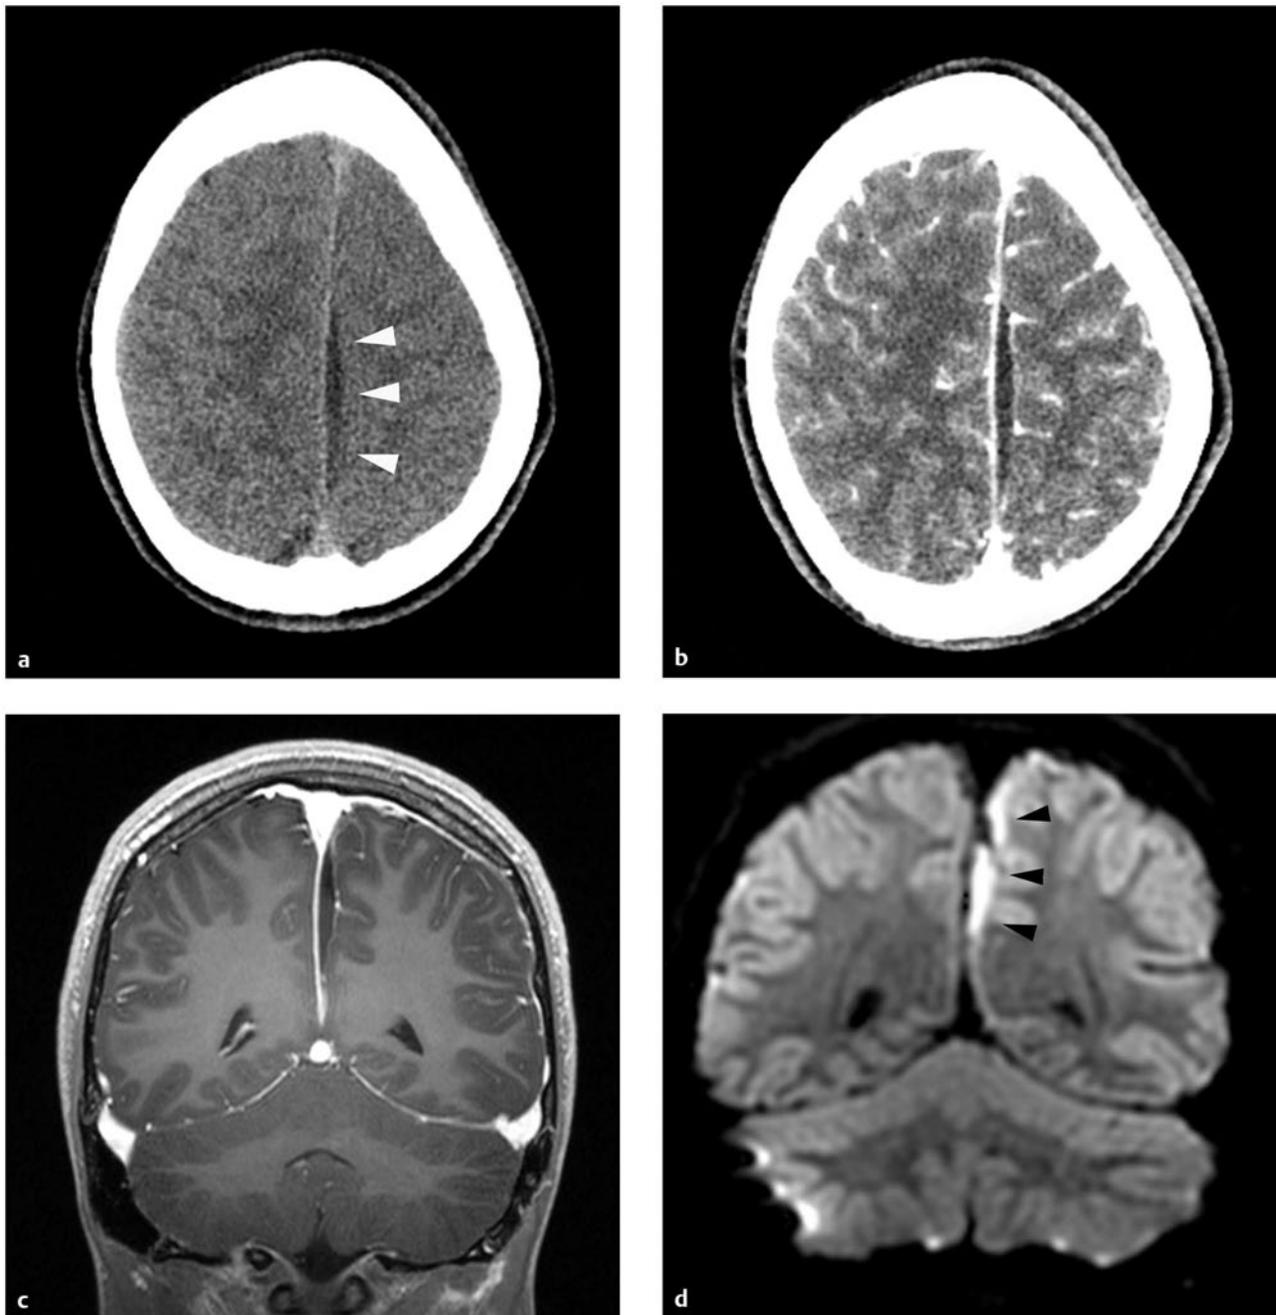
(a) This school-age boy had headache and fever. He was lethargic at presentation, and there was a right lower limb monoparesis. After functional endoscopic sinus surgery for his associated frontal and ethmoid sinusitis, he received a 6-week course of parenteral antibiotics. There was no neurosurgical intervention. He recovered completely. Computed tomographic scan of the brain without contrast shows a small, low-density collection in the interhemispheric fissure (*white arrowheads*). (b) There is pachy- and leptomeningeal enhancement after contrast administration. (c) Likewise, there is pachy- and leptomeningeal enhancement on this coronal, T1-weighted magnetic resonance imaging sequence. The collection itself is low-intensity compared with brain. (d) On diffusion-weighted imaging, the interhemispheric pus is high-intensity (*black arrowheads*).
